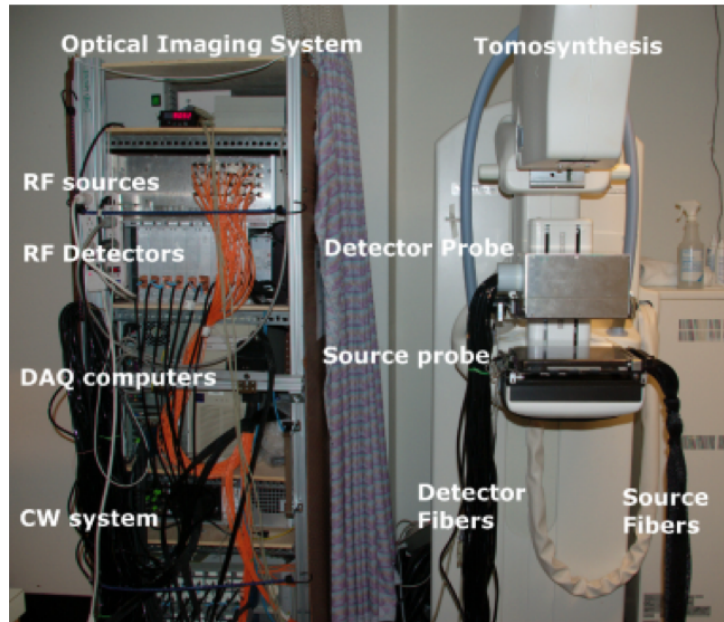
Picture of the combined DOT/x-ray system in clinical environment, including both RF and CW source/detector modules and the fiber optics interface attaching to the x-ray system. (Duplicated from [11])
